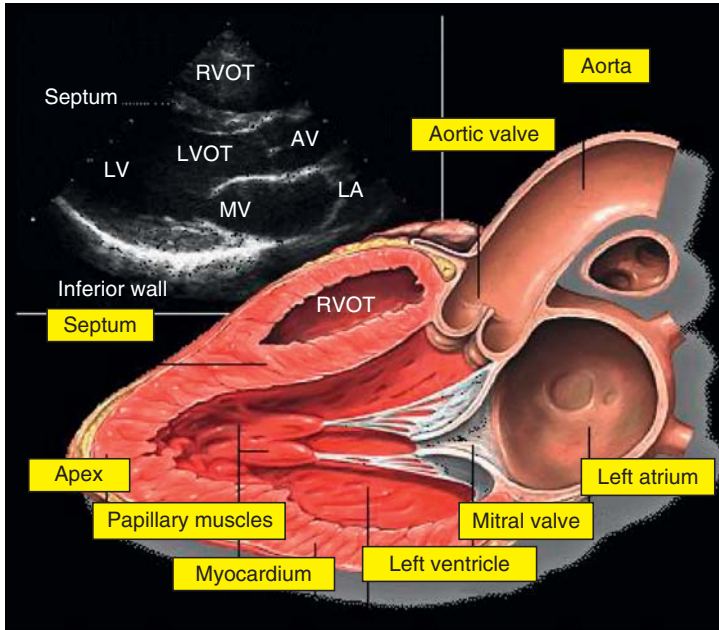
Echocardiography image (top) is obtained by placing the ultrasound probe on the surface of the chest over the heart. Image shows all four chambers of the heart, useful for detecting chamber enlargement. Valvular disease, hypertension, arrhythmias, left ventricular function, ejection fraction, and cardiac output can be determined and measured. These cardiac measurements offer a noninvasive, cost-effective and reliable approach that can identify often correctable or treatable early lesions of the heart which may contribute to chronic brain hypoperfusion and possibly AD in the elderly patient with mild memory complaints. Key: RVOT = right ventricular outlet tract; LVOT = left ventricular outlet tract; LV = left ventricle; MV = mitral valve; LA = left atrium.
